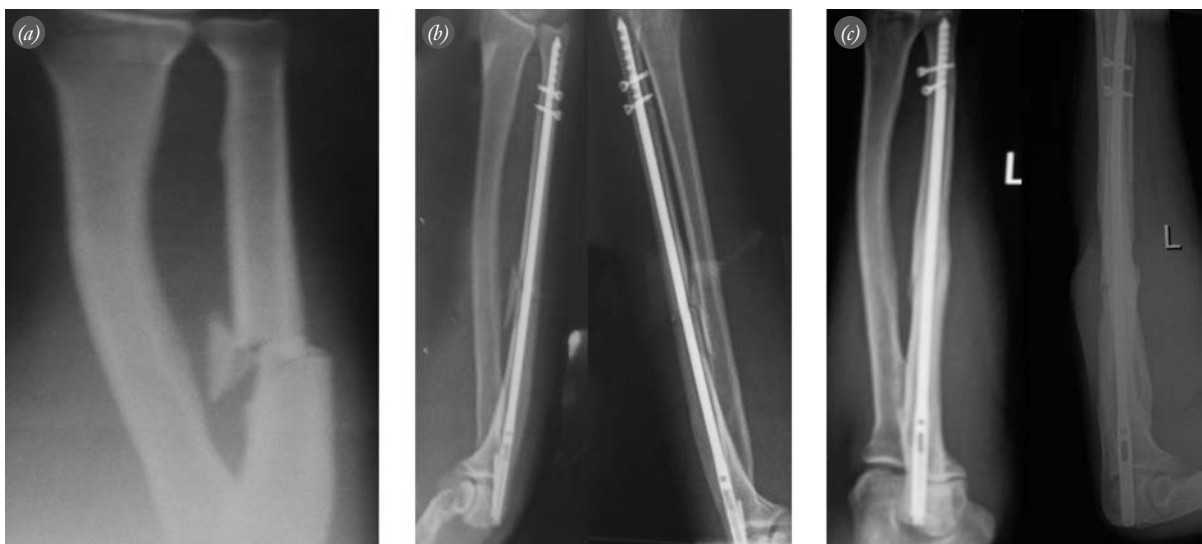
A 40-year-old man with an isolated ulnar diaphyseal fracture. (a) Preoperative radiographs of the ulna fracture. (b) The fracture was reduced and fixed with the new intramedullary nails using closed technique. (c) At 14 months postoperative, healing and alignment were satisfactory. Grace and Eversmann grade was excellent, and DASH score was 2.5.
